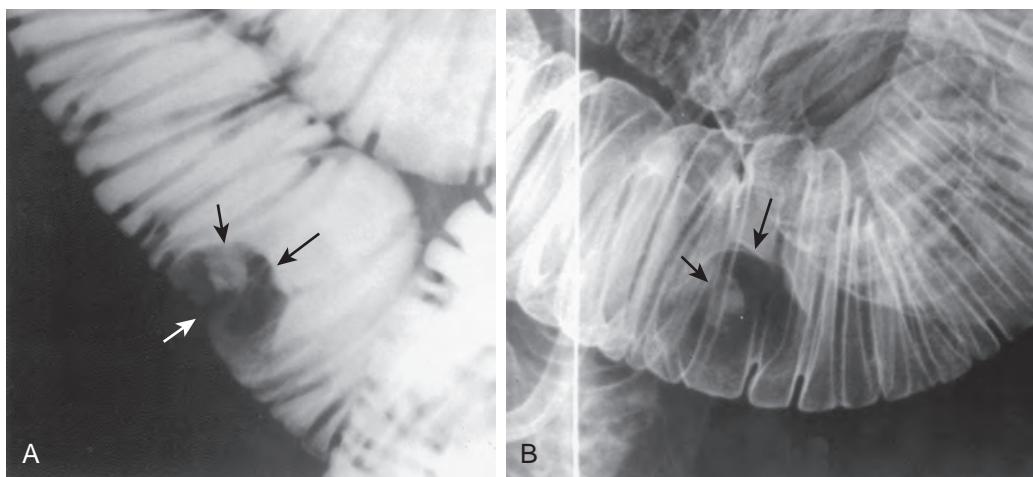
Metastatic melanoma demonstrated during enteroclysis. A. Spot image obtained during the single-contrast phase of enteroclysis shows a polypoid mass as a lobulated radiolucent filling defect (long black arrow) in the barium column. The normal luminal contour is disrupted (white arrow). A central barium collection is seen (short black arrow). B. Spot radiograph obtained during the methylcellulose phase again shows a slightly lobulated radiolucent filling defect (long arrow), with a central barium collection (short arrow), representing an ulcer. Apart from the ulceration, the surface of the polyp is smooth, indicating the submucosal origin of the lesion.
